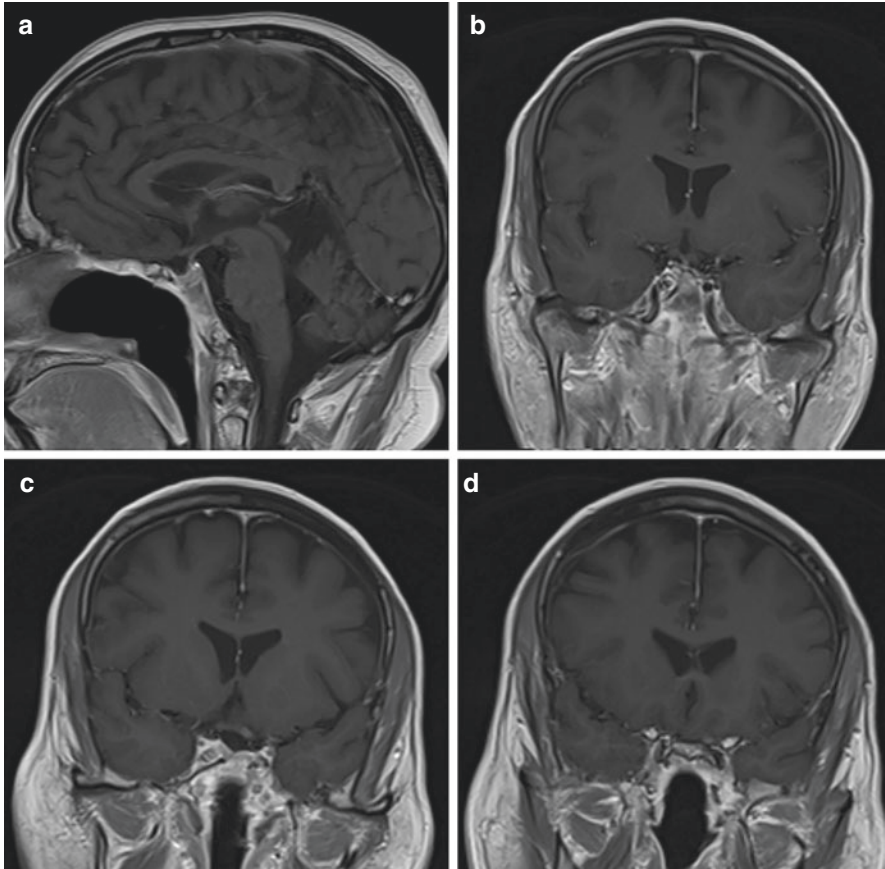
Clival metastasis from a renal clear cell carcinoma. Postoperative T1-weighted MRI with contrast in sagittal (a) serial coronal (b–d) images demonstrating near total resection of the tumor
